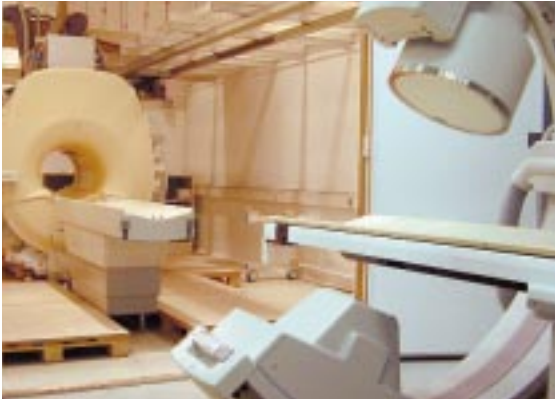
The combined MRI/X-ray angio suite. (Photograph taken at the Philips Medical Systems facility in Best during production and assembly).
